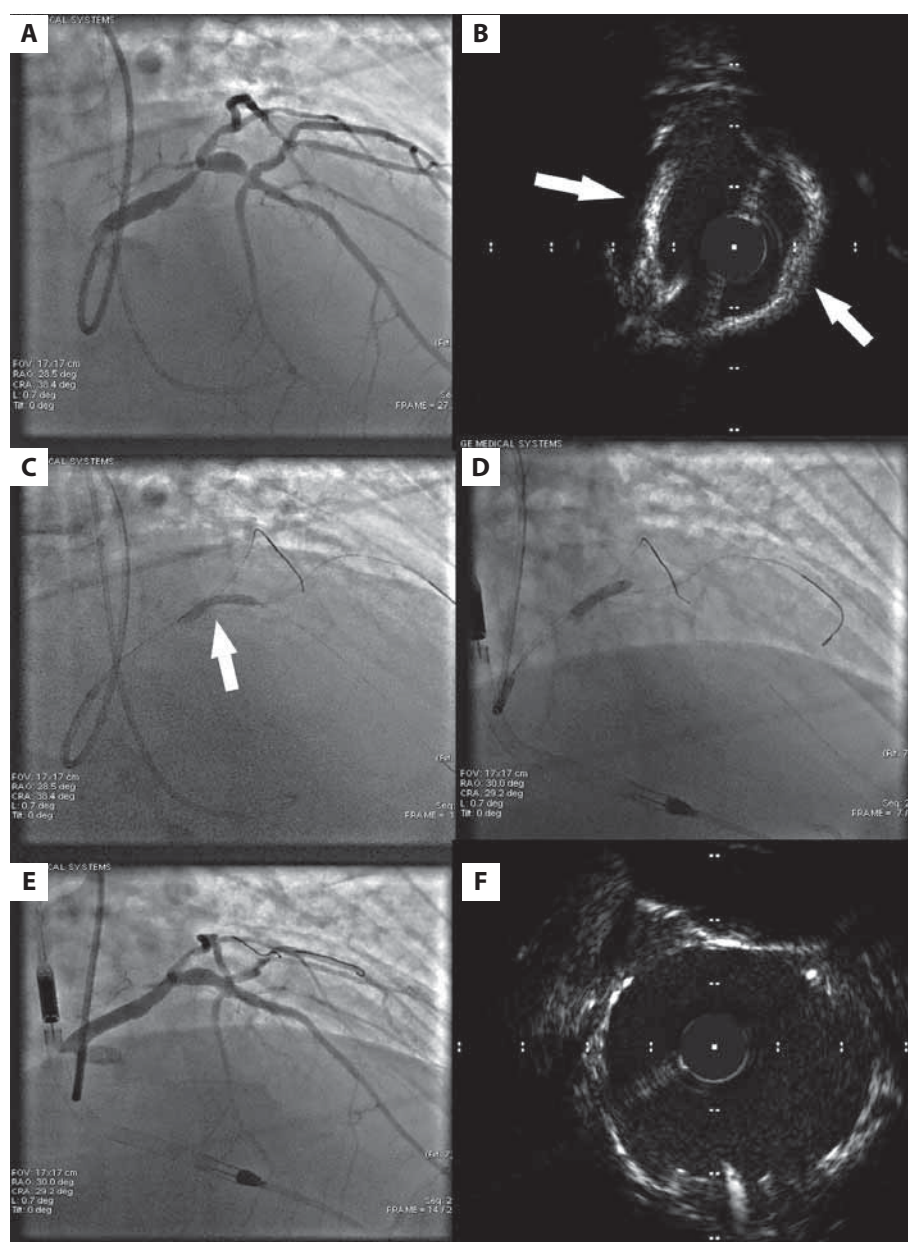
A. Coronary angiography revealing tight stenoses in the left main and left anterior descending arteries. B. Intravascular ultrasound with visible excessive calcifications in the left main (white arrows). C. Not fully deployed balloon (white arrow) during predilatation and with a pigtail catheter in the left ventricle. D. Full balloon opening after using intravascular lithotripsy with a functioning Impella device. E. Final coronary angiography after implantation of 3 stents. F. Intravascular ultrasound showing proper stent apposition in the calcified plaques.
